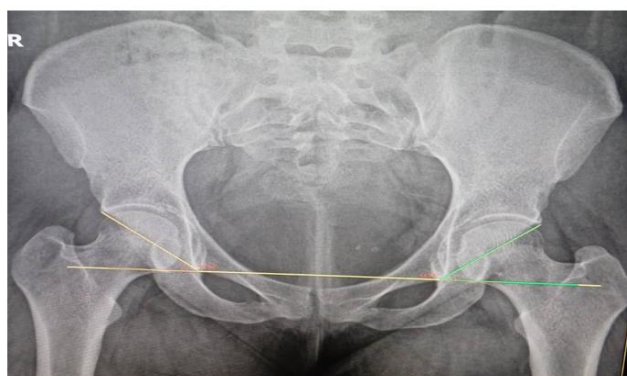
A pelvic radiograph that displays the lines utilized to measure the acetabular angle of Sharp
